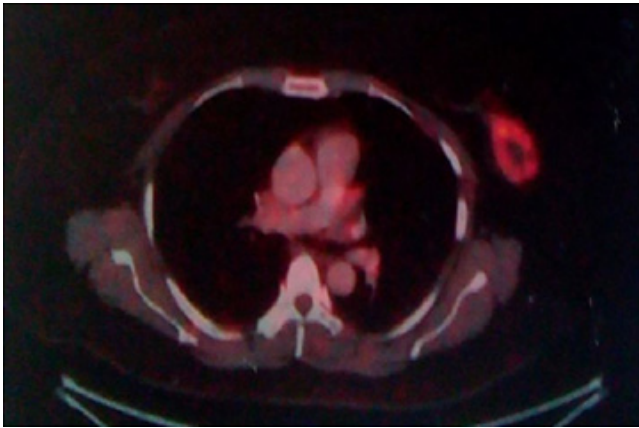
FDG-PET scan showed FDG avid soft tissue density lesion (size 4.2 cm × 2.8 cm SUV_{max} 13.2) in left breast. FDG-PET: fluorodeoxyglucose-positron emission tomography; SUV: standardized uptake value
